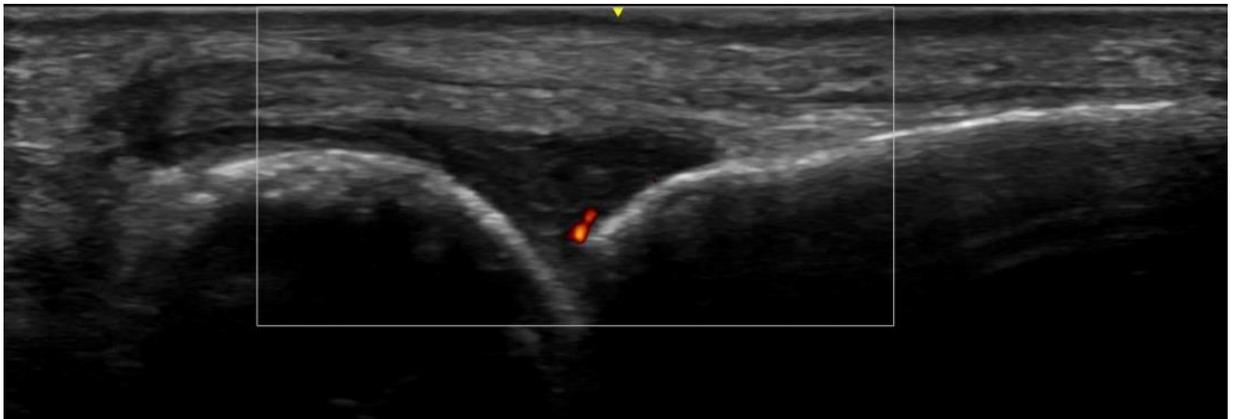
Longitudinal dorsal scan of the fourth metacarpophalangeal joint of the right hand, showing synovial thickening grade two (moderate), no joint effusion, and grade one (mild) power Doppler (Author's own, 2025).
